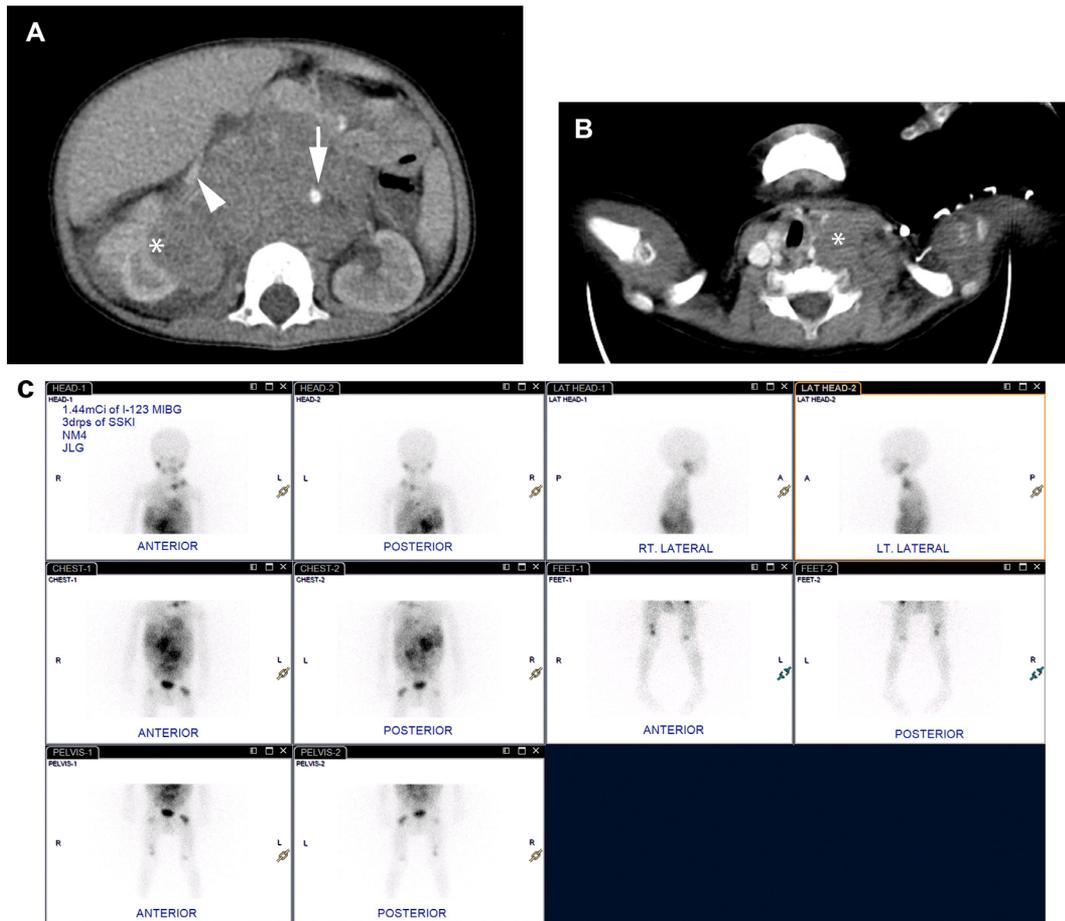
Metastatic disease consistent with stage M in a 1-year-old male with primary retroperitoneal neuroblastoma with extensive metastatic disease. (A) Contrast-enhanced CT of the abdomen shows solid mass *encasing* the aorta (arrow) (presence of an IDRF), *flattening* the inferior vena cava but with a visible lumen (arrow head) (not an IDRF), and *infiltrating* the right kidney parenchyma (*) (presence of an IDRF). (B) Contrast-enhanced CT of the neck showing abnormally enlarged supraclavicular lymph node (*) with associated displacement and compression of the trachea (presence of an IDRF). (C) MIBG study demonstrates increased tracer uptake in multiple bones, within left neck and superior mediastinum adenopathy, and throughout the mid abdomen. Positive MIBG in the bones makes this a stage M, rather than MS.
